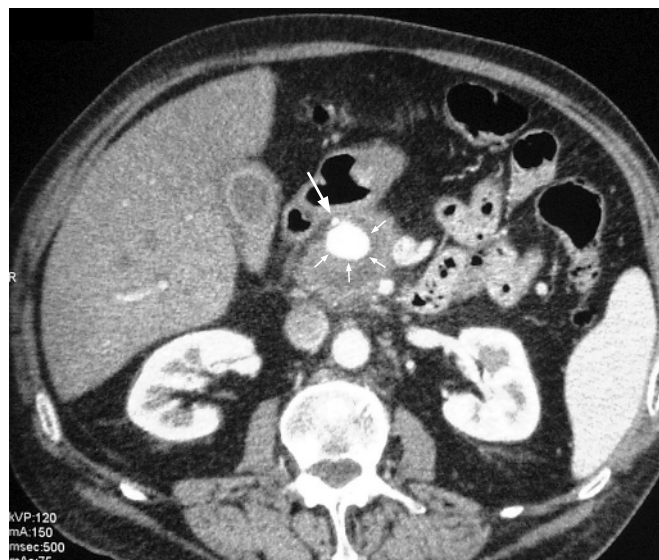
Contrast enhanced multi-slice abdominal CT scan showing the gastroduodenal artery (large arrow), with the 6.5 cm intimately related enhancing mass (small arrows).
